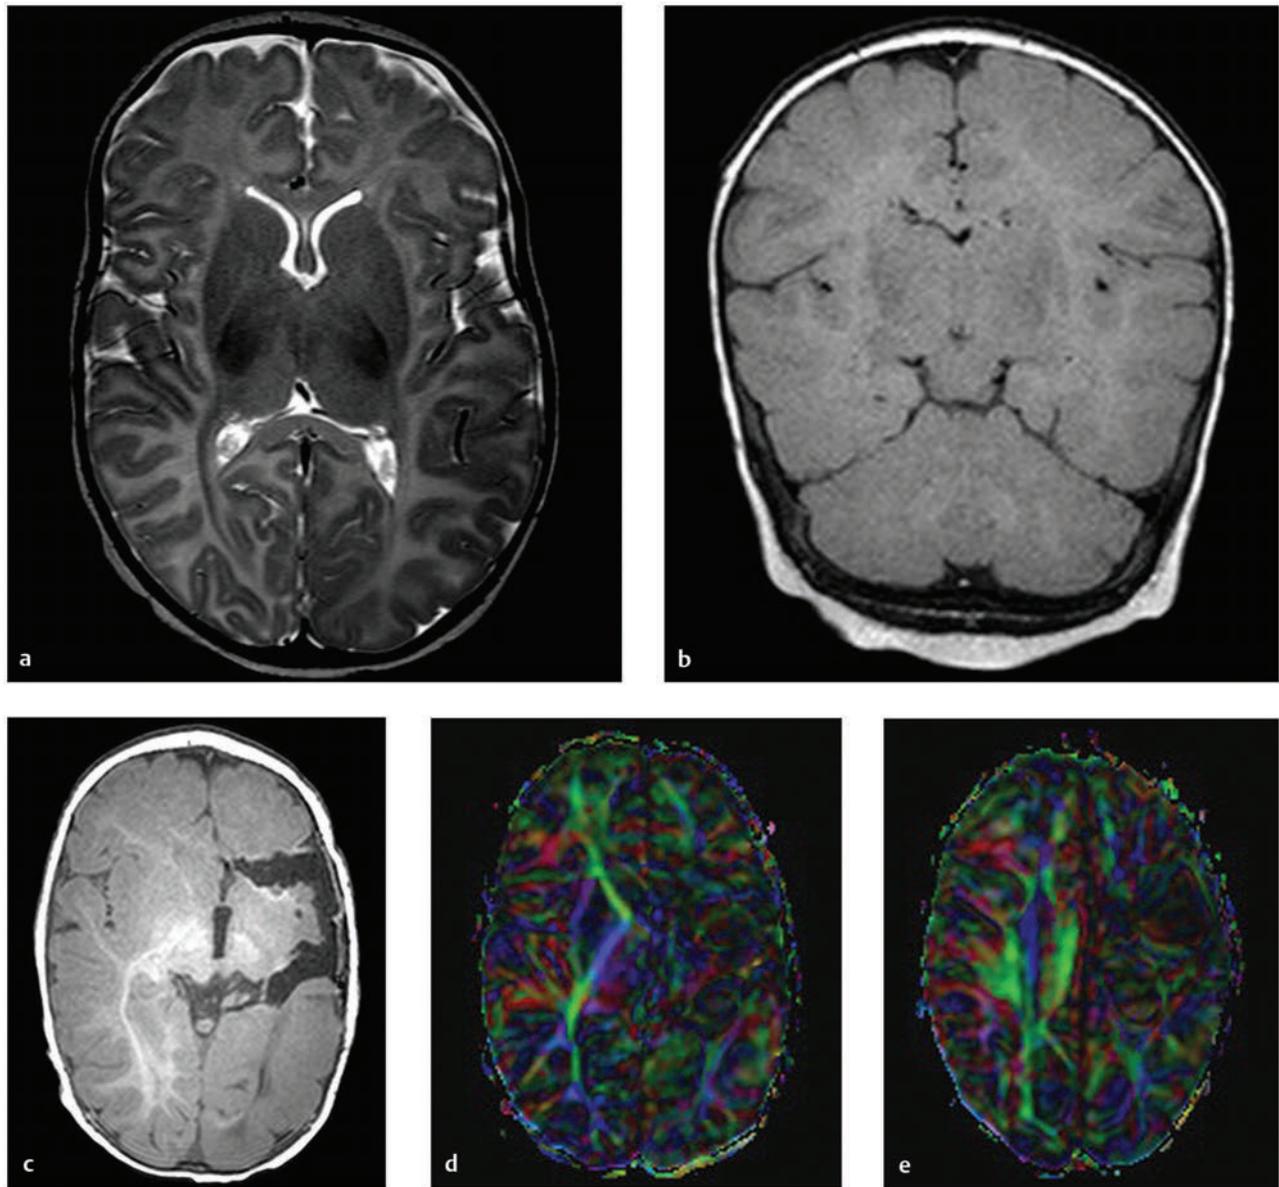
Hemimegalencephaly. (a) Axial T2-weighted image showing thickening in the left occipital, temporal, and parietal lobes. (b) Coronal FLAIR (fluid-attenuated inversion recovery) image revealing enlargement of the left occipital and temporal lobes. (c) T1-weighted image 6 months after hemispherotomy. (d,e) Diffusion tensor imaging elucidating the functional disconnection of the left hemisphere.
